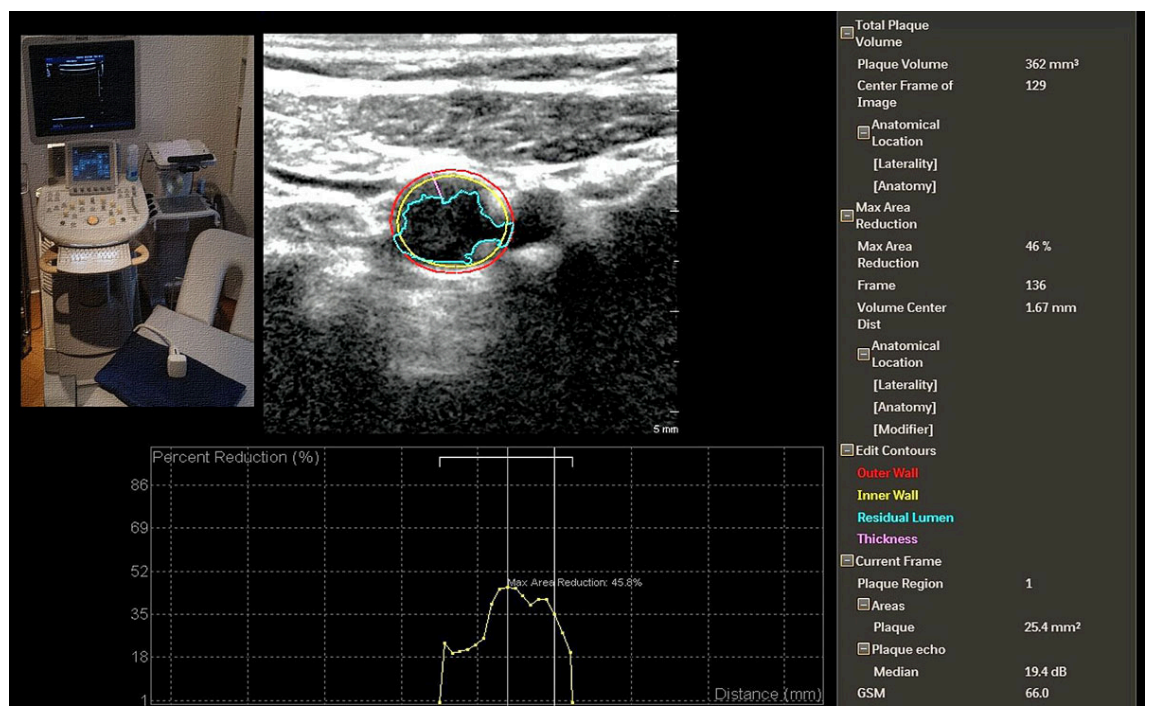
Semiautomatic measurements of transversal plaque areas obtained from a Philips iU 22 ultrasound system equipped with the single sweep volumetric transducer vL 13-5. Analysis was performed offline with software provided by the manufacturer. The software calculates the total plaque volume from all transversal carotid plaque areas obtained by the single sweep volumetric transducer over a field of view of 3.8 cm.
